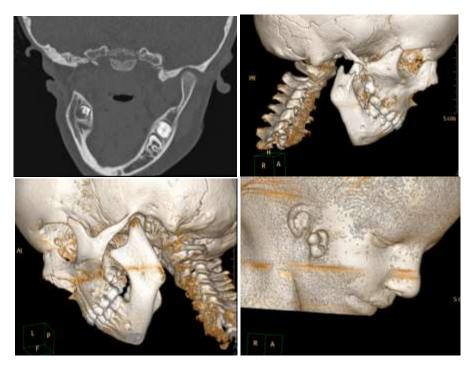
Coronal HRCT and volume rendered images in a 3 years old child depicting bilateral mandibular hypoplasia, EAC atresia and microtia. Bilateral middle ear cavities were also hypoplastic.
